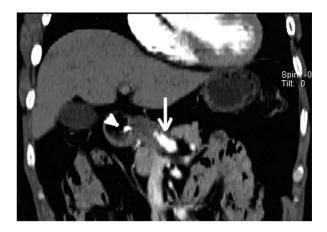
A reconstructive coronal view of CT scan with contrast showed a 5.8 x 2.2 x 2.6 cm heterogeneously enhancing mass lesion (arrow) contacting the medial aspect of duodenal bulb with encasement of enlarged hepatic artery. There was a residual hemoclip (smaller arrow head) in the duodenum.
